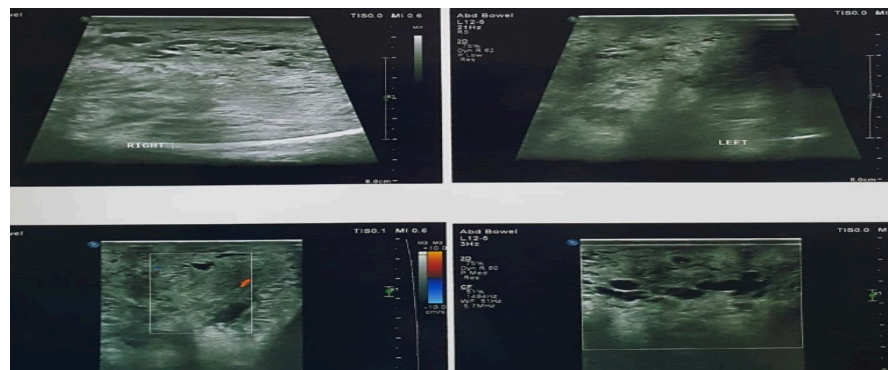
Ultrasound revealed no testes either in the scrotal sac or abdomen.
